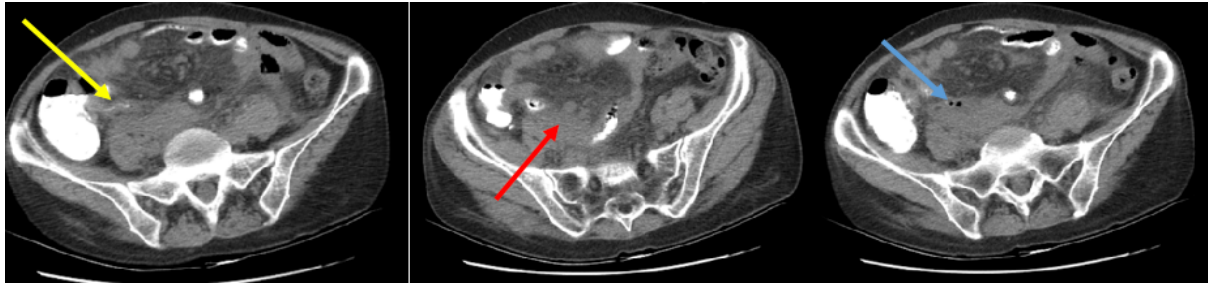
Abdominal CT scan (axial view) prior to surgery showing inflamed appendix (yellow arrow), phlegmon in the right iliac fossa (red arrow), and free air inside the phlegmon (blue arrow) caused by perforation. No signs of pneumoperitoneum.
